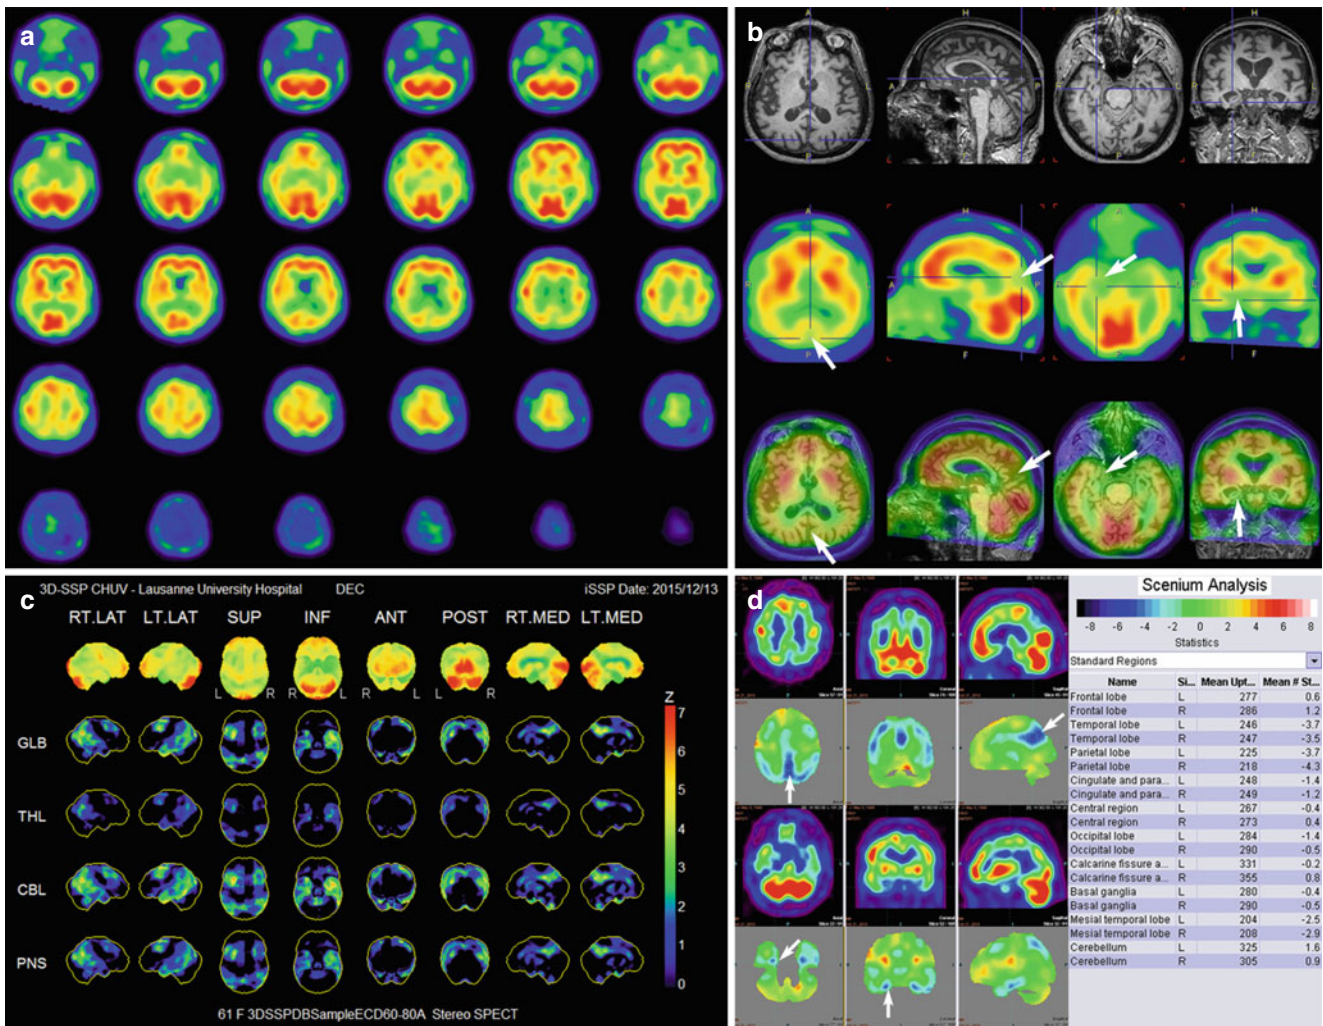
Case of a 61-year-old woman with memory problems, aggressive behaviour, visual hallucination and agitation, with progressive degradation of symptoms over the last 2 years. The ^{99m}Tc-ECD SPECT (a) shows an important decrease of perfusion in the posterior cerebral cortex and temporoparietal cortex, as well as on the mesial side of the temporal lobe. These are accompanied of severe atrophy on the SPECT/MR fusion
